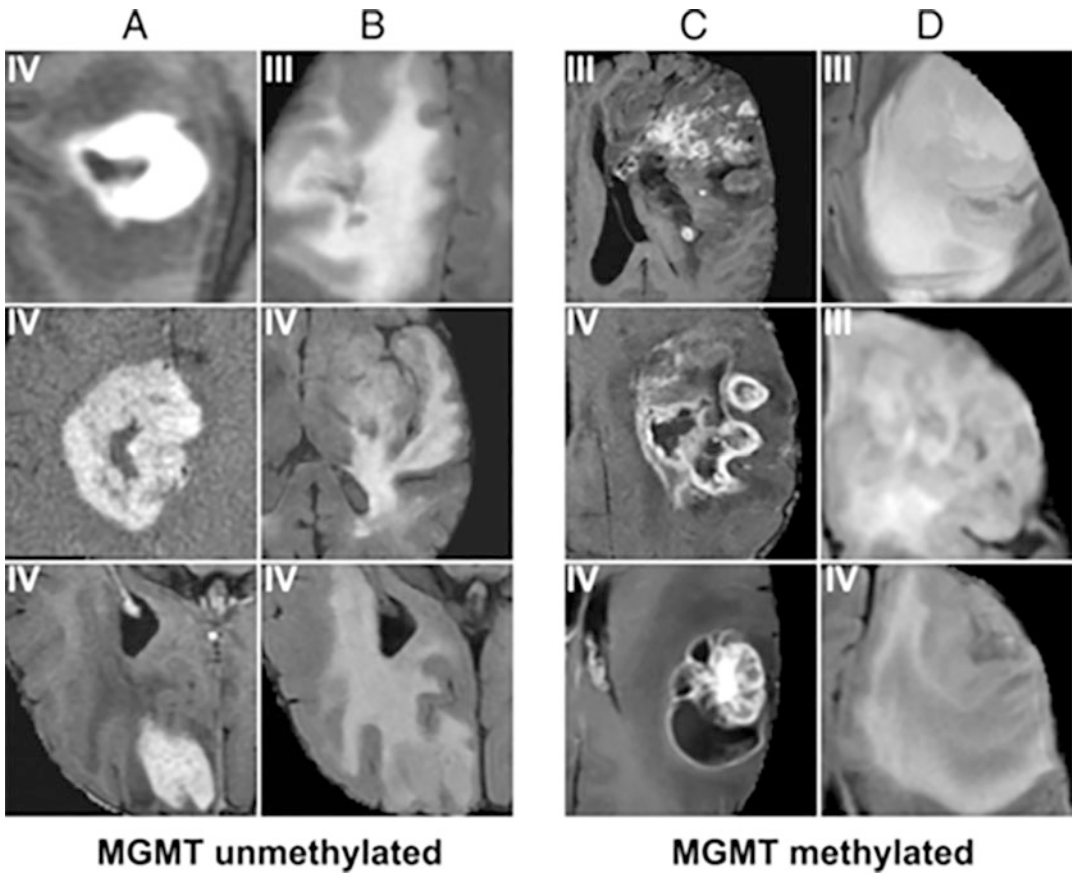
MRI separating gliomas by MGMT methylation status. Features include thick enhancement with central necrosis (a) with infiltrative edema patterns (b). In contrast, features predictive of MGMT promoter methylated status include nodular and heterogeneous enhancement (c) with masslike FLAIR edema (d). (Copyright American Journal of Neuroradiology, adapted, with permission, from reference [35])
